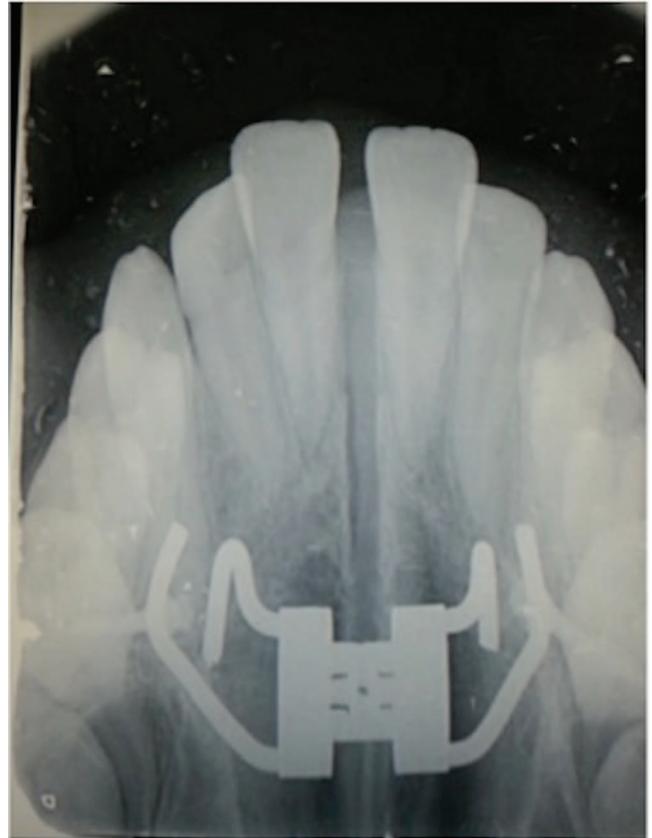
Upper occlusal radiograph taken after 1 week.
